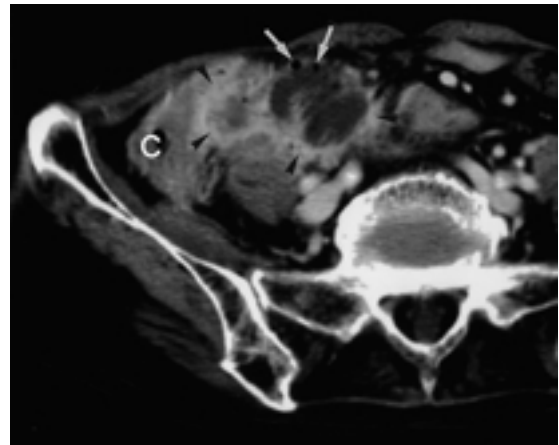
Perforated appendicitis in a 65-year-old woman. Contrast-enhanced CT scan shows an abscess (arrowheads) containing two air bubbles (arrows) in the medial aspect of the cecum (C). Inflammatory changes are also seen in the adjacent mesenteric fat.
